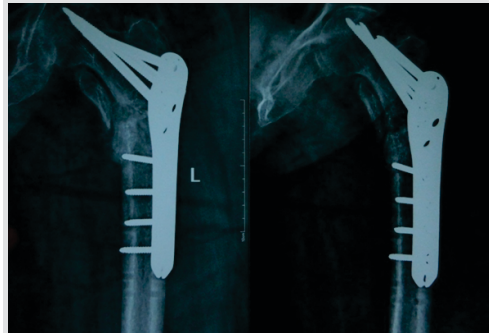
Pre-operative X-ray of nonunion of proximal femoral region with implant in situ.
